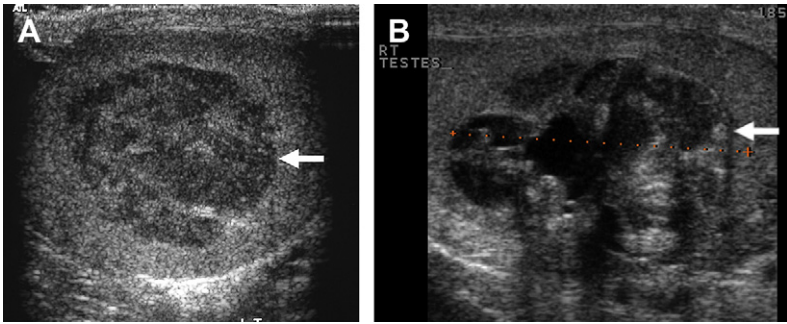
TGCT tumors on ultrasound. Ultrasound images through the testes in two different patients showing mass lesion (*arrow*) in the testes. At pathology (A) seminoma and (B) non-seminomatous germ cell tumors were found.
